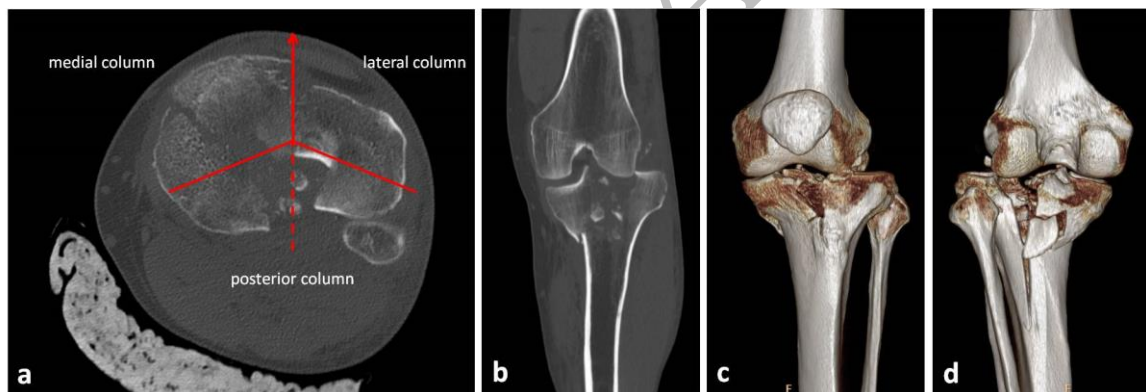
Pre-operative, all the fractures were classified with the three-column classification system using two-dimensional (a, b) and three-dimensional computed tomography images (c, d).
